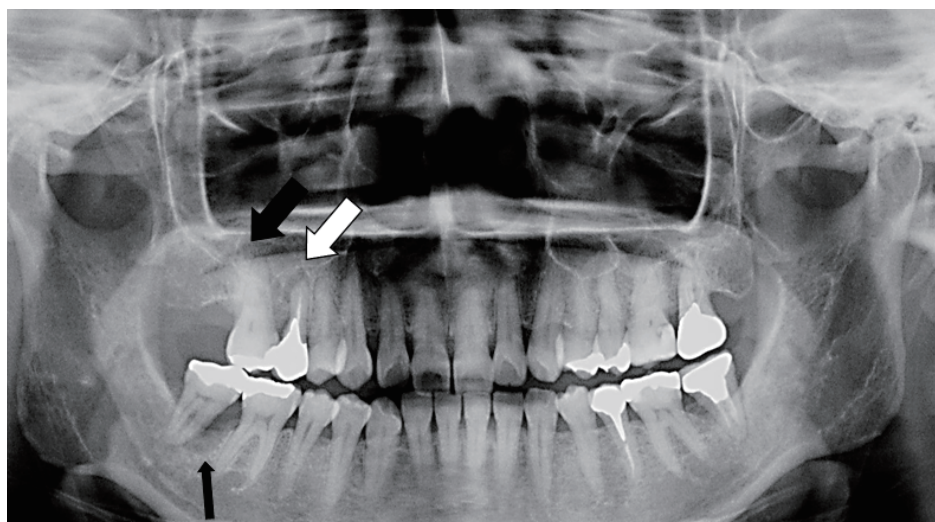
Orthopantomography. There were X-ray transparent lesions around the roots of the upper right second premolar (white arrow), the upper right first molar (black thick arrow), and the lower right second molar (black thin arrow), and the findings of chronic apical periodontitis were observed.
